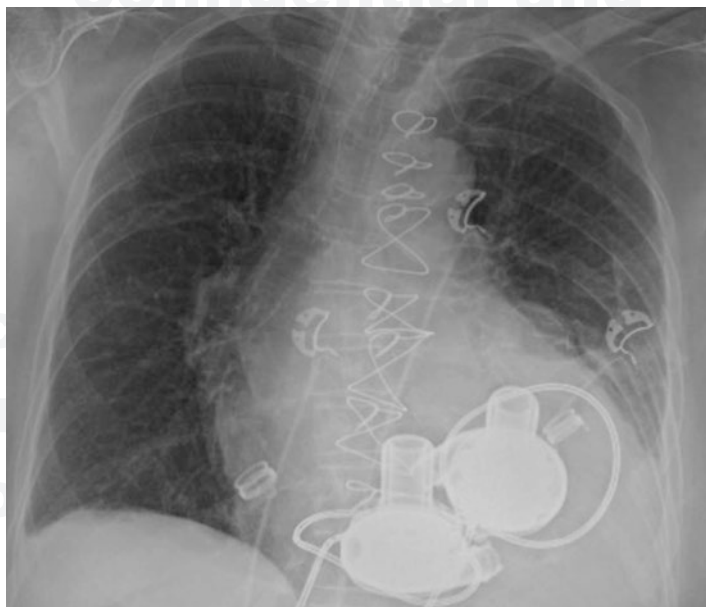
Chest radiograph showing a patient with a two HVADs used in a biventricular configuration
